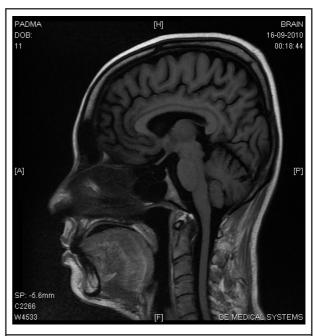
MRI Brain showing empty sella (red arrow) in our patient.
